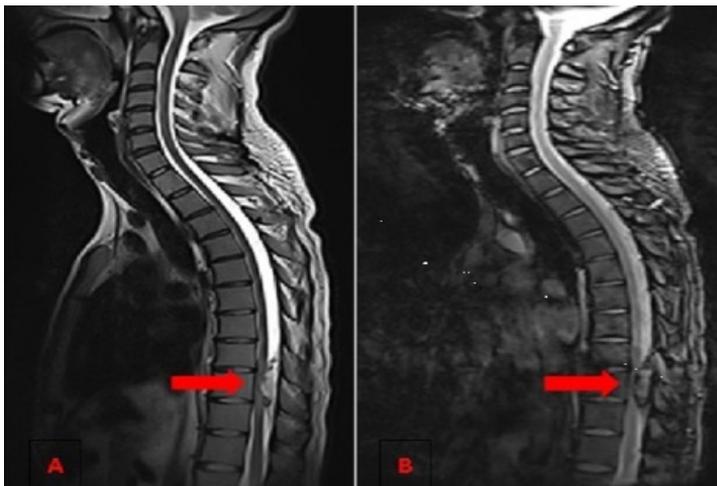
(A) Sagittal view T2 weighted MRI of thoracic shows intraspinal extradural lesion at T8 - T10 level suggestive of hematoma and compressing the cord (red arrow). (B) Sagittal view T2 gradient echo MRI of thoracic shows intraspinal extradural lesion at T8 - T10 level suggestive of hematoma and compressing the cord (red arrow)
